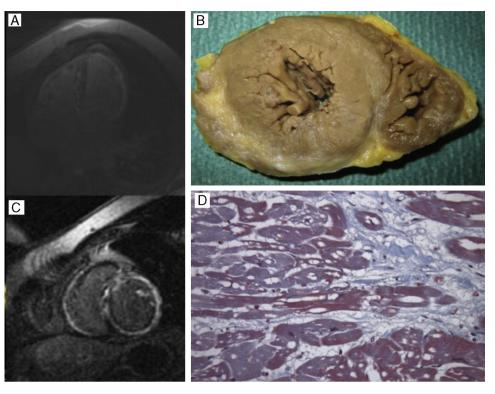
A and C: Cardiac magnetic resonance imaging of the proband of family 1 (*DES* Ile367Phe mutation) who shows biatrial and biventricular dilatation and extensive transmural fibrosis in the free wall of the left ventricle, septum, and right ventricle. B and D: Necropsy of the proband of family 4 (*DES* Arg415Glu mutation), revealing normal myocardial thicknesses and diameters, fiber hypertrophy, and severe subepicardial fibrosis, cytoplasmic vacuolization, and myofibrillar loss, which are all compatible with left ventricular arrhythmogenic cardiomyopathy.
